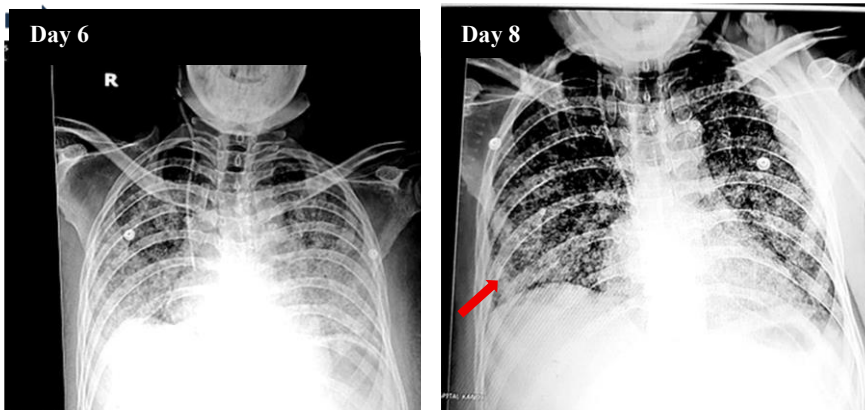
Chest x-rays taken 2 days apart showing miliary mottling
